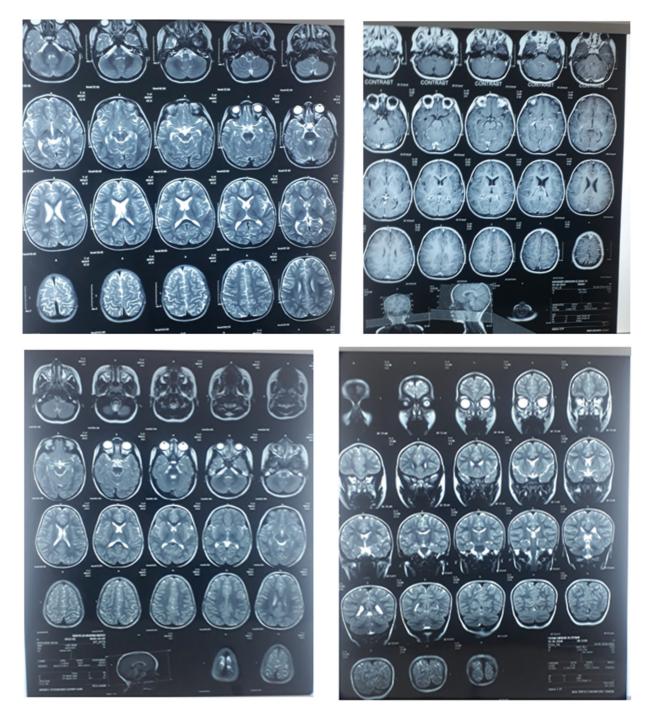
Family C. Magnetic resonance imaging (MRI) brain of patient C1 showed normal study. MRI brain of patient C2 showed normal study also.
